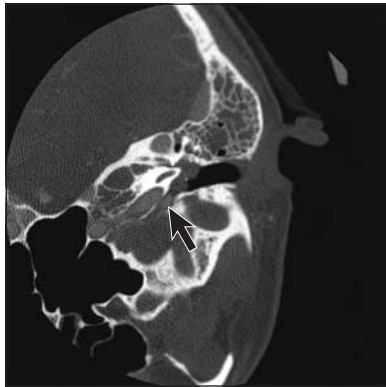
Axial contrasted computed tomogram showing petrous carotid artery pseudoaneurysm (arrow).
